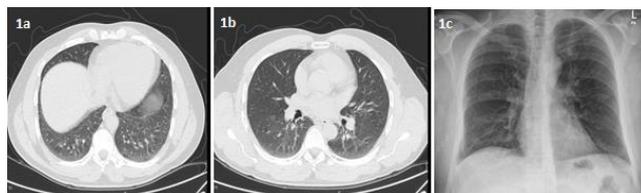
b and c: Radiological imaging of the case; Thorax HRCT images show that moderate peribronchial thickening in both lungs and mosaic perfusion pattern in the lower zones (a and b), PA chest X-ray, ILO classification: p/p 1/1
